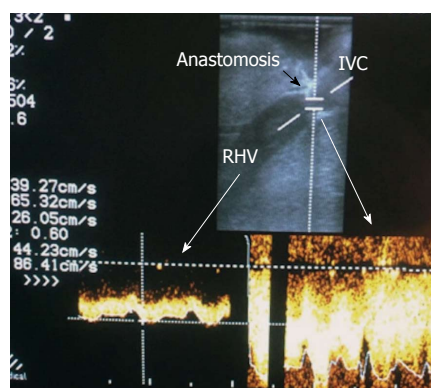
Normal right hepatic vein anastomosis. Intra-operative color Doppler image demonstrating normal augmentation of the RHV flow at the site of anastomosis (2-fold) compared to the intrahepatic flow, with preserved phasic flow pattern. IVC: Inferior vena cava; RHV: Right hepatic vein.
